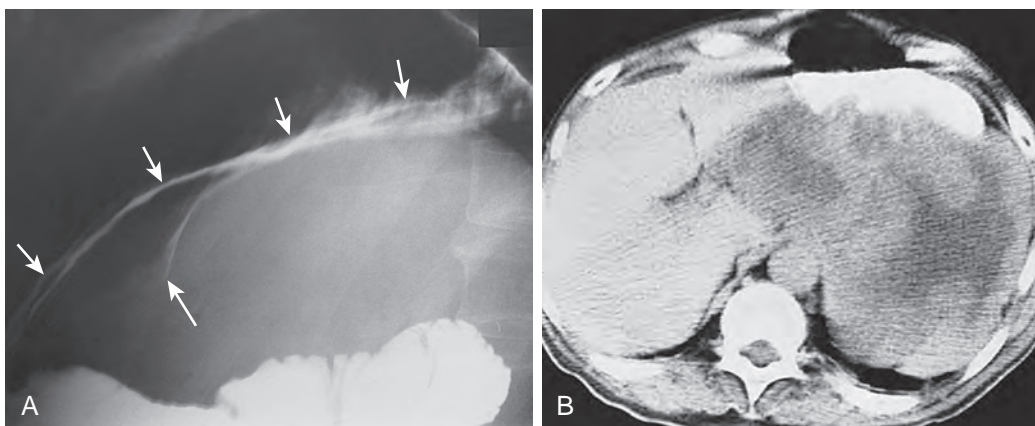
Exogastric malignant gastrointestinal stromal tumor. A. Lateral radiograph of the stomach shows a giant exogastric mass compressing the posterior wall of the gastric fundus (short arrows). A central dimple or spicule (long arrow) is seen at the site of attachment of the mass. This finding should suggest the possibility of an exogastric GIST. B. CT scan reveals a giant heterogeneous mass with multiple low-density areas caused by necrosis of tumor. This heterogeneous appearance is characteristic of malignant GISTs on CT. (Courtesy Hans Herlinger, MD, Philadelphia.)
